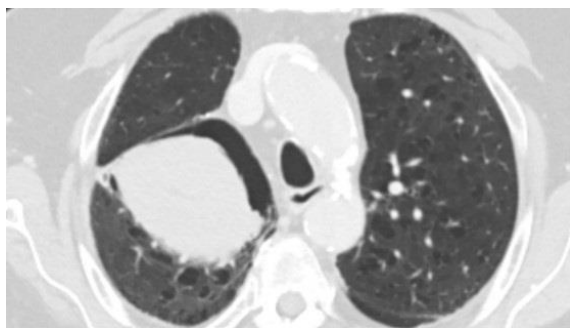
Representative image from thoracic CT in lung windows. To view Figure 3 in a separate, enlarged window click [here](#).
